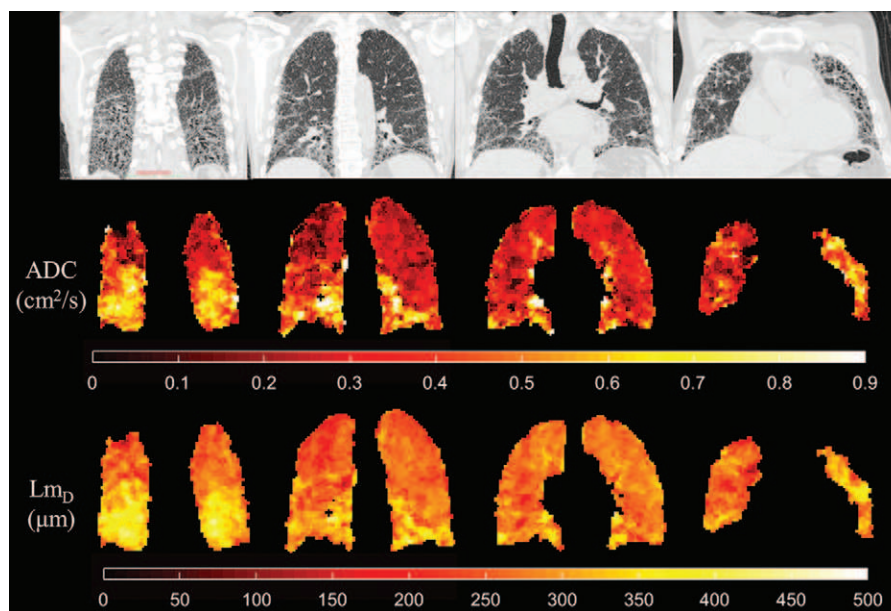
CT images and helium 3 (^3He) diffusion-weighted MR images acquired at baseline in a 74-year-old male study participant with idiopathic pulmonary fibrosis. Coronal CT images (top; section thickness, 1.25 mm) show fibrotic regions of the lung. Corresponding coronal ^3He apparent diffusion coefficient (ADC) and mean diffusive length scale (Lm_D) maps (middle and bottom; section thickness, 12 mm) show areas of elevated values that are spatially correlated to the fibrotic regions at CT.
